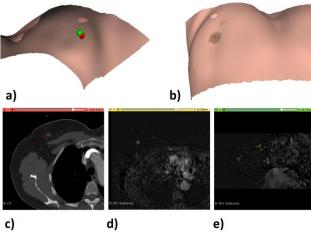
Results of case 13. a) Intraoperative surface (back face) with the actual and estimated tumors; b) intraoperative surface with tumor projection on the skin (front face); c) right breast in the CT; d) right breast in MRI (axial); e) right breast in MRI (sagittal). The actual tumor is shown in green and the estimated one in red.
